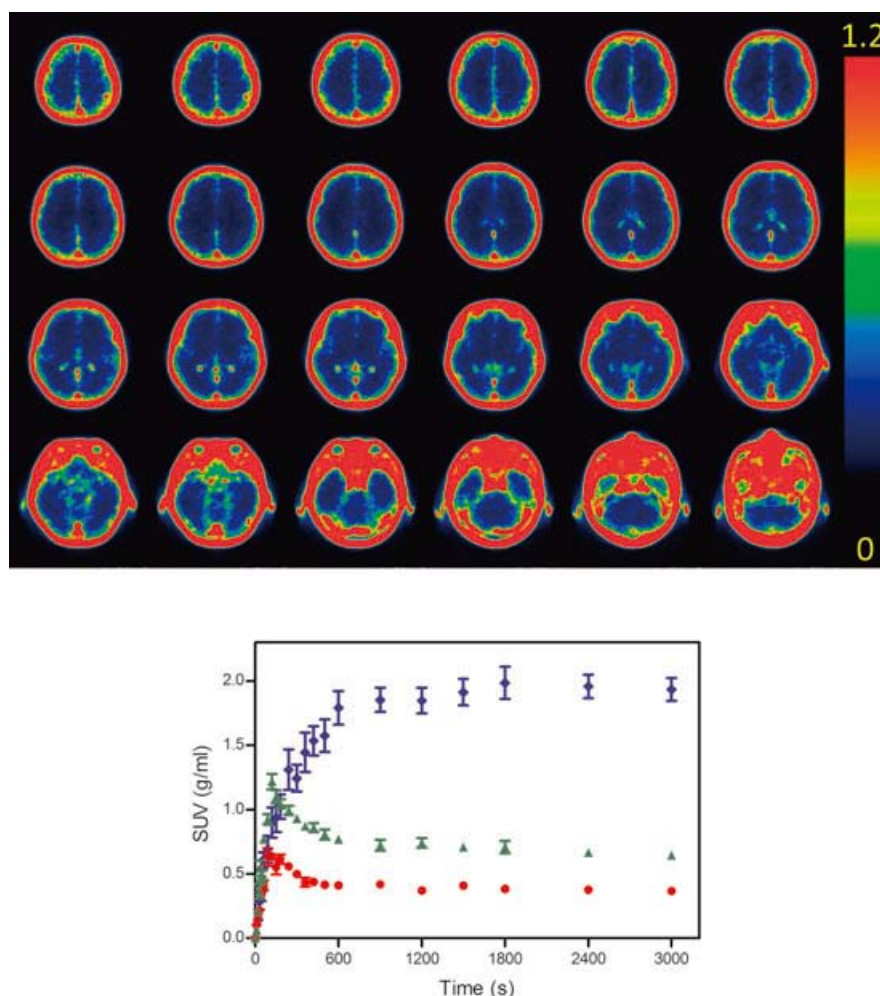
Upper: Representative ^{11}C -TGN-020 PET images of normal human brain images are constructed based on the frames acquired 15–60 minutes post-injection. All five subjects studied exhibited virtually identical findings. Images are color coded according to standardized uptake value (SUV) of each pixel in the range of 0–1.2. Over ranged ($1.2 > \text{SUV}$) pixels are expressed as red. Strongest uptake was seen in the skull and within large veins and dural sinuses. Radioactivities within large veins and dural sinuses are believed to reflect AQP-1 of red cells. The cause for strong uptake within the skull remains to be elucidated. Lower: Time-activity curves of uptake in SUV of three representative regions. Red circle: cortex, green triangle: choroid plexus, blue diamond: skull. Data are shown as mean SUV \pm standard error of means (SEM).
